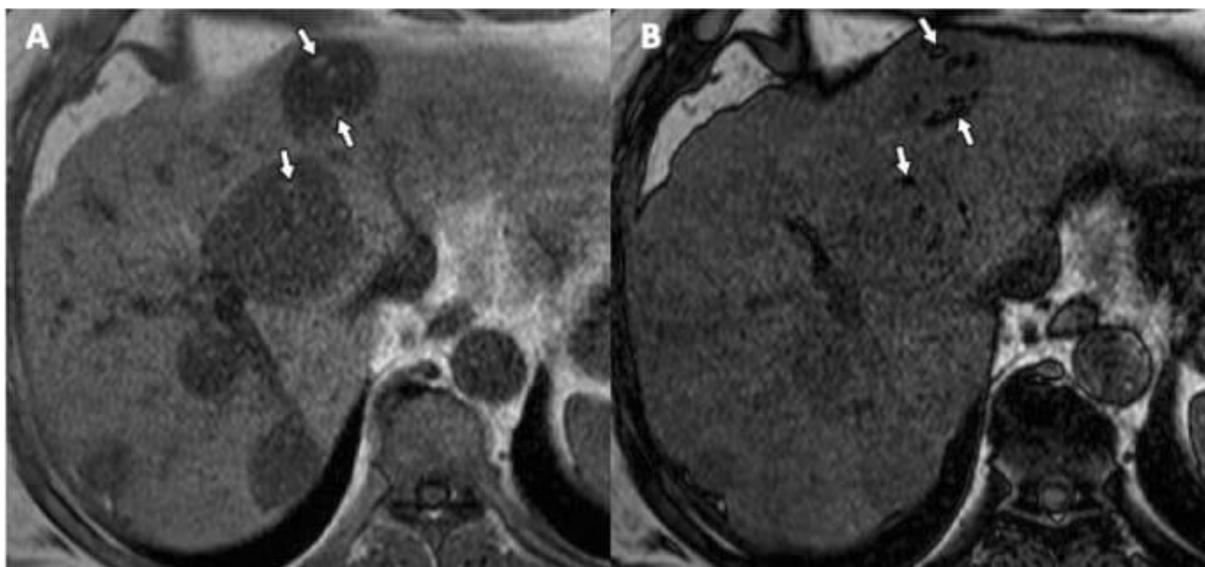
A) Axial gradient-echo in-phase T1-weighted MR image shows multiple high signal intensity foci (arrows) within hepatic hydatid cyst. B) Axial gradient-echo opposed-phase T1-weighted MR image shows macroscopic fat within the same lesions, a finding confirmed by chemical shift artifact and signal cancellation (arrows) surrounding the lipid pure component.
